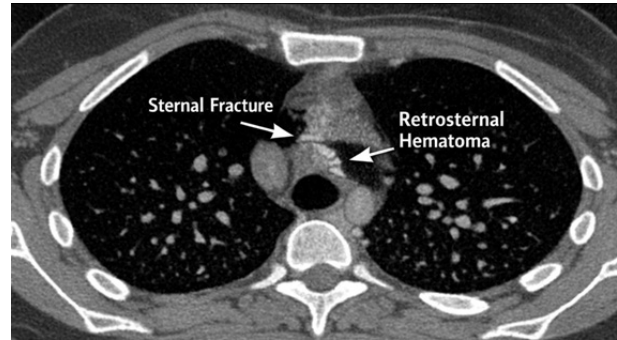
Axial CT image demonstrating a displaced fracture of the sternal body, characterized by cortical discontinuity and an associated hyperdense retrosternal collection, consistent with a hematoma.
